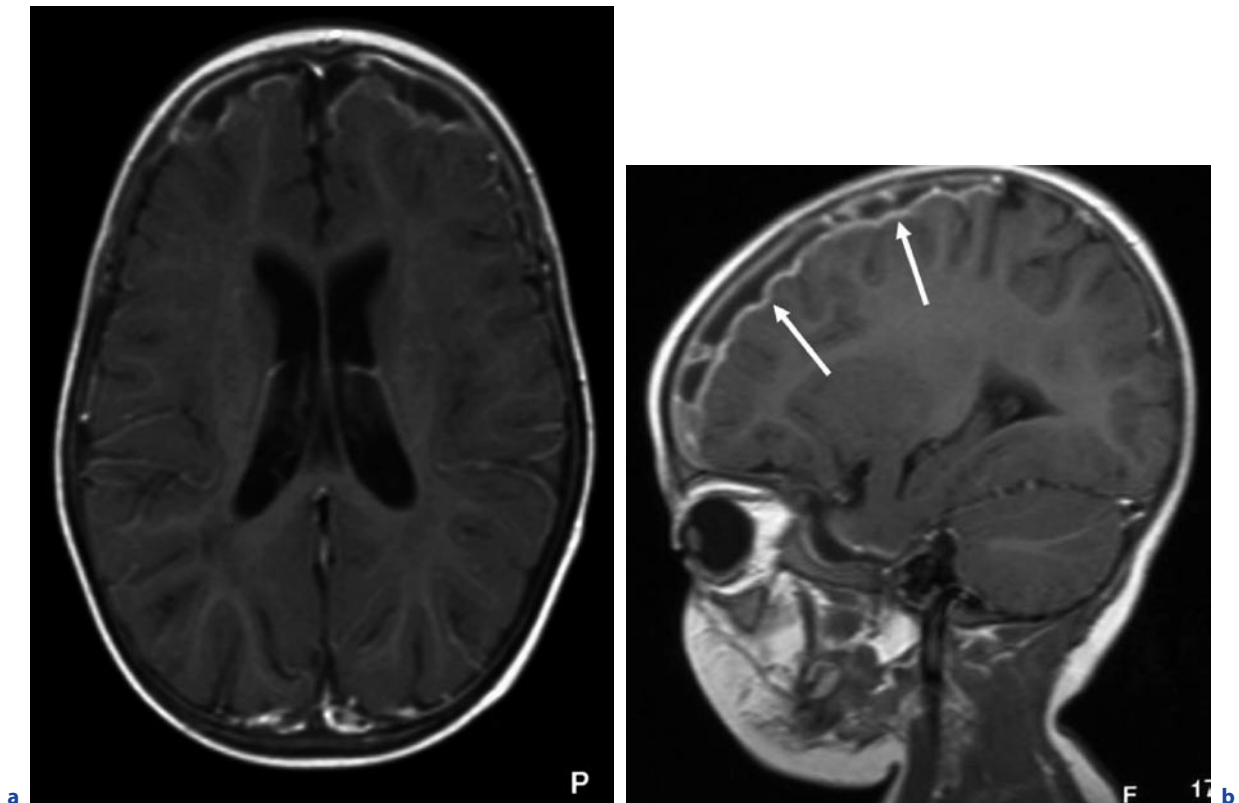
Pneumococcal meningitis in a 5-year-old child. a Axial T1-weighted image after contrast administration. b Sagittal T1-weighted image after contrast administration. c,d see next page
